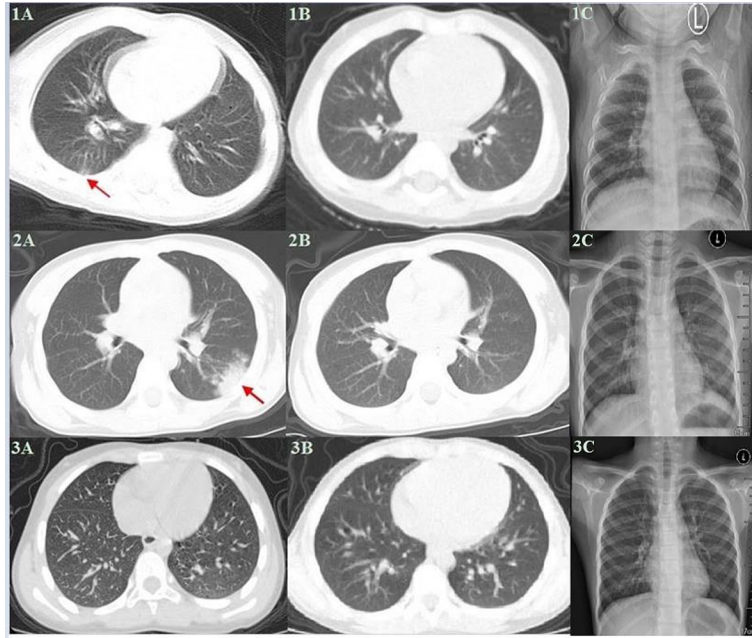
Transverse Chest Computed Tomography and X-ray Images
